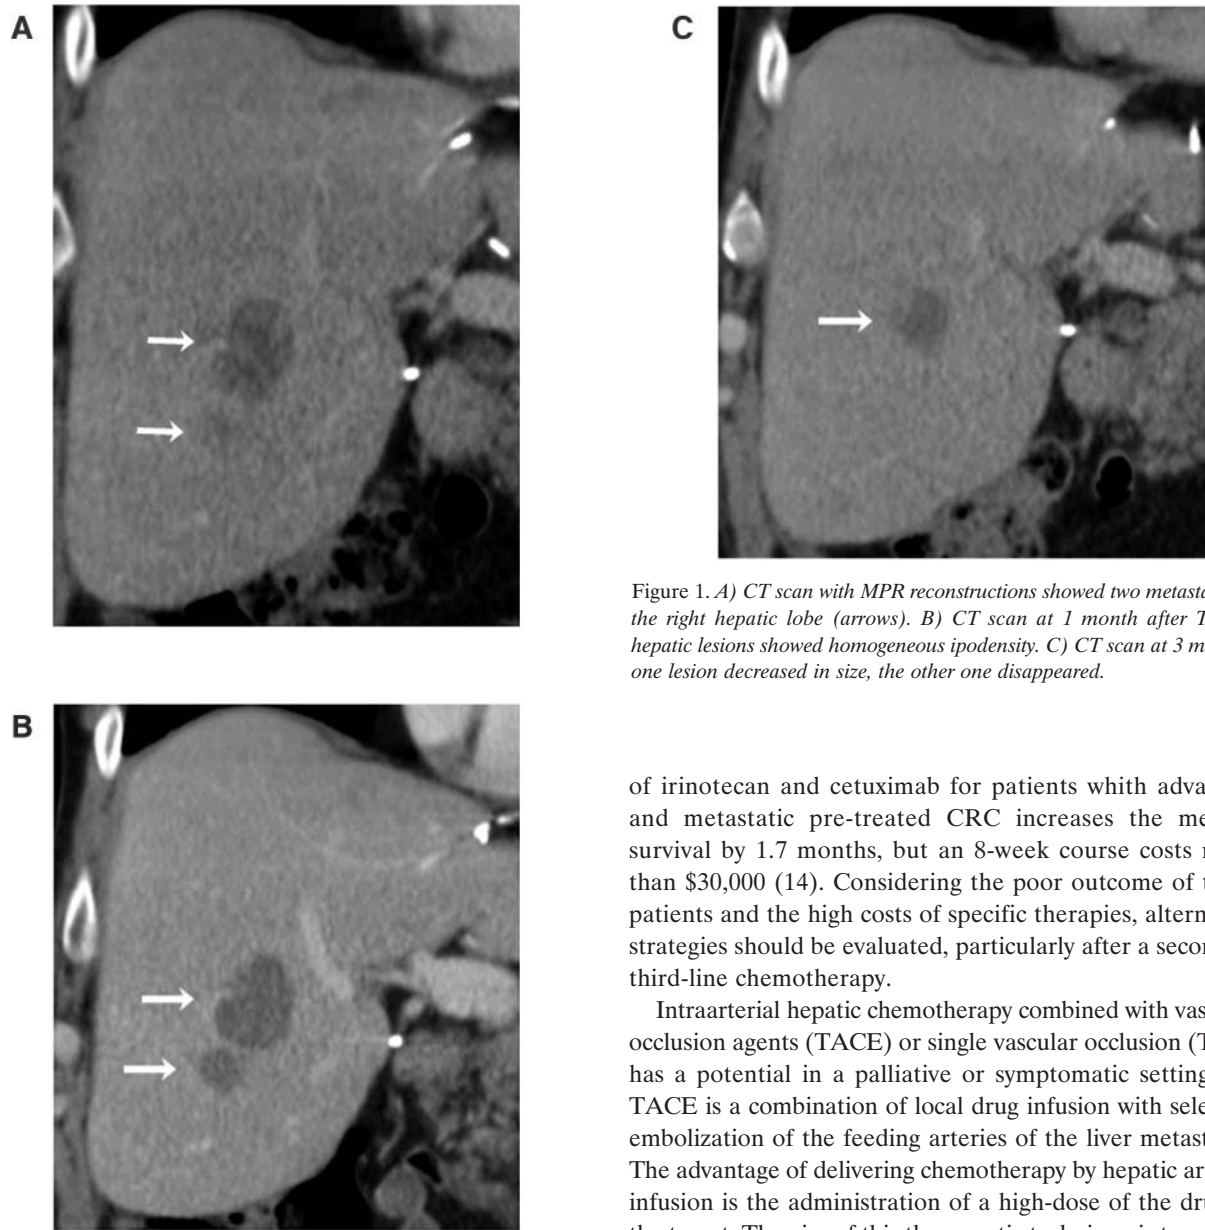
A) CT scan with MPR reconstructions showed two metastases in the right hepatic lobe (arrows). B) CT scan at 1 month after TACE, hepatic lesions showed homogeneous hypodensity. C) CT scan at 3 months: one lesion decreased in size, the other one disappeared.
